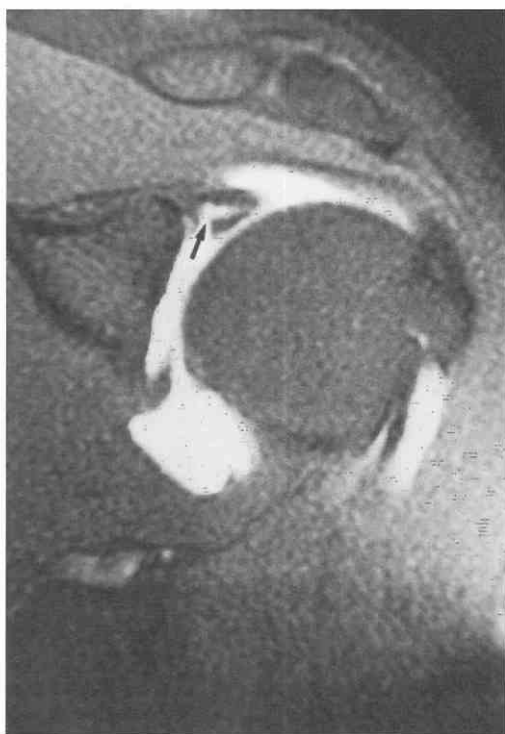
SLAP (superior labrum, anterior and posterior) lesion. T1-weighted (TR = 500 msec, TE = 14 msec), fat-saturated coronal oblique MR arthrogram image. Gadolinium (*arrow*) enters the substance of the labrum and turns laterally, away from the glenoid. In this case, the high signal continues to the anterior edge of the labrum, suggesting a bucket-handle tear or type III SLAP lesion.
